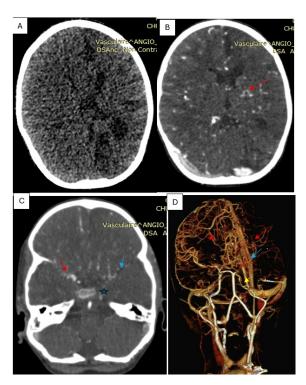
Computed tomography brain scan, axial section in parenchymal window without
